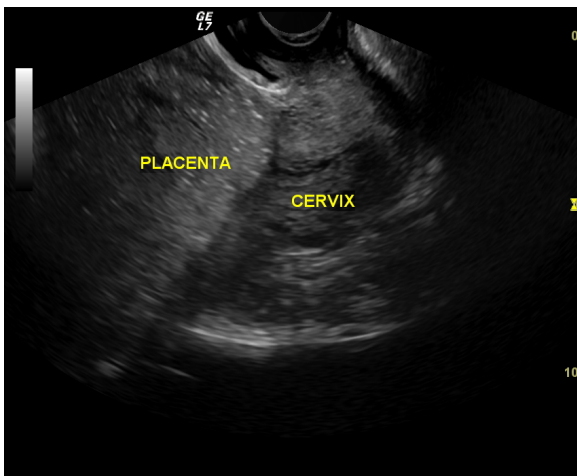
An ultrasonographic transvaginal scan image showing a placenta previa at 28 weeks of pregnancy.
